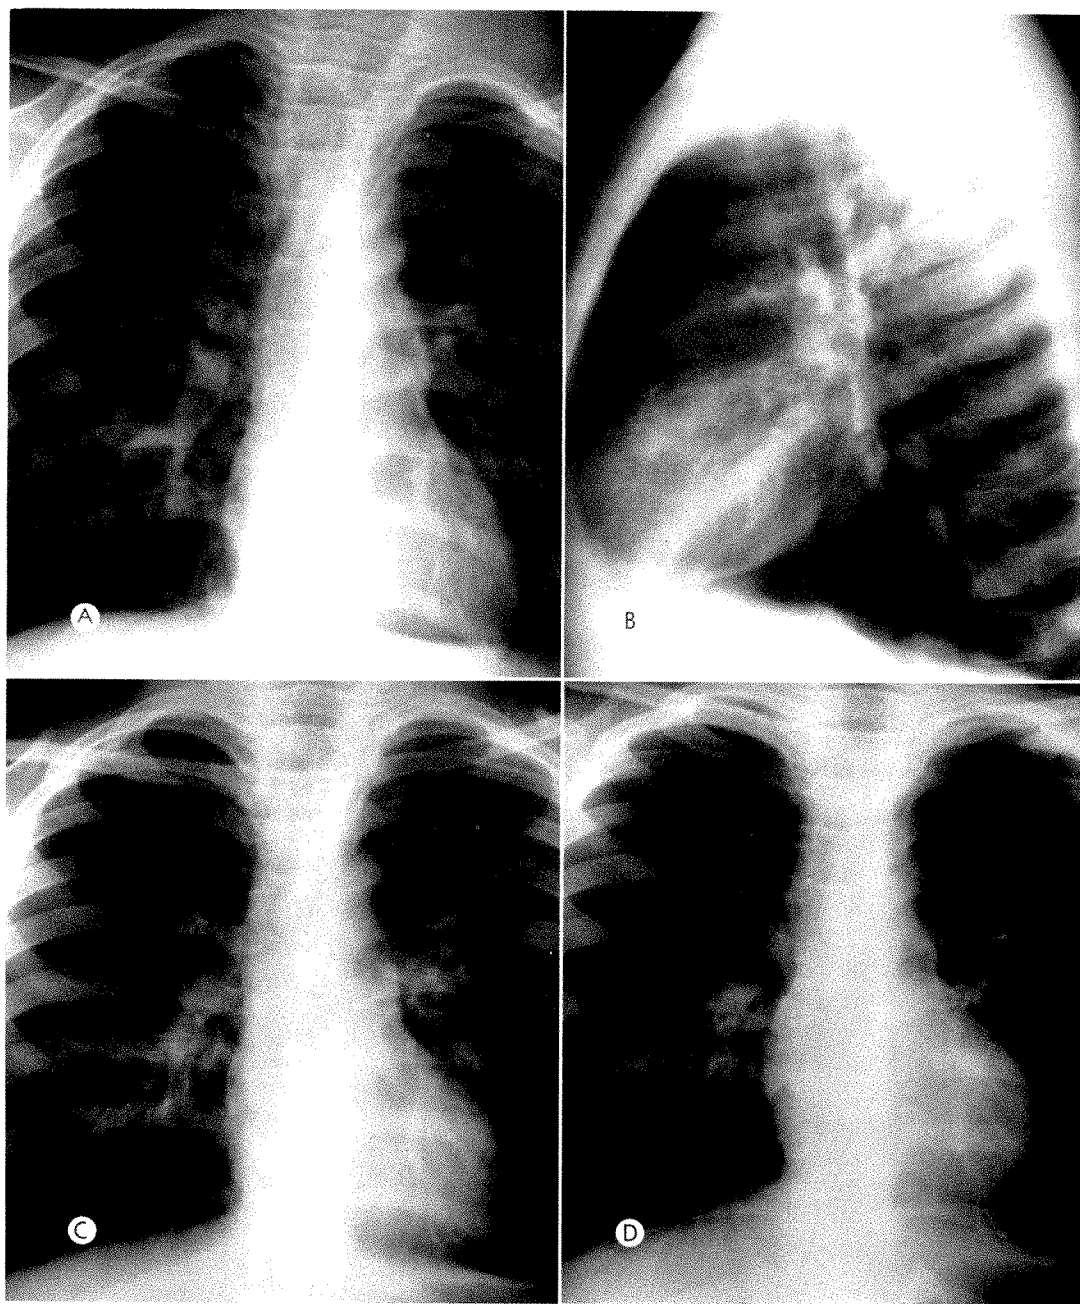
A.A., 3 year old white male with recurrent asthma and a cold of 3 days' duration. (A) Anteroposterior roentgenogram showing mild pulmonary overaeration. (B) Lateral study. (C and D) Two years later. Exhalation results in very little diaphragmatic motion and in a reduction of heart size and vascular markings.
